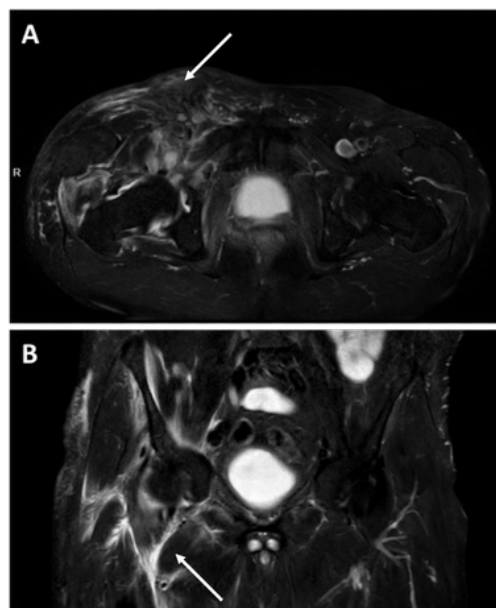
Axial STIR (A) and coronal DIXON T2 (B) MRI sequences hip both sides.
